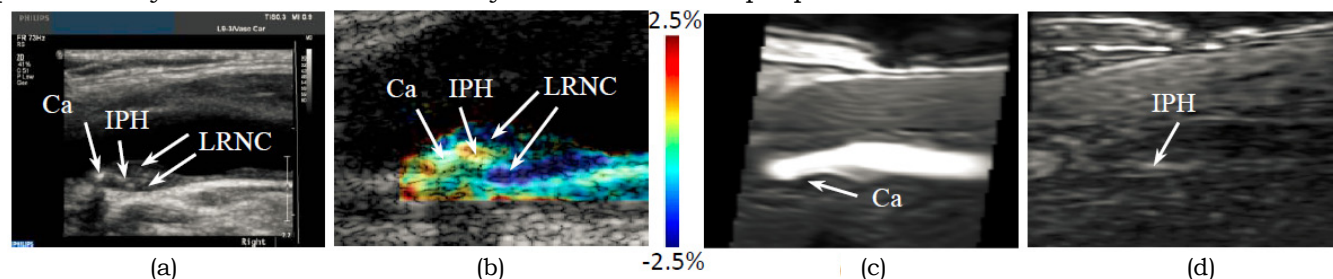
(a) B-mode image, (b) strain image overlaid onto the B-mode image, (c) TOF MR image, (d) MP-RAGE MR image
